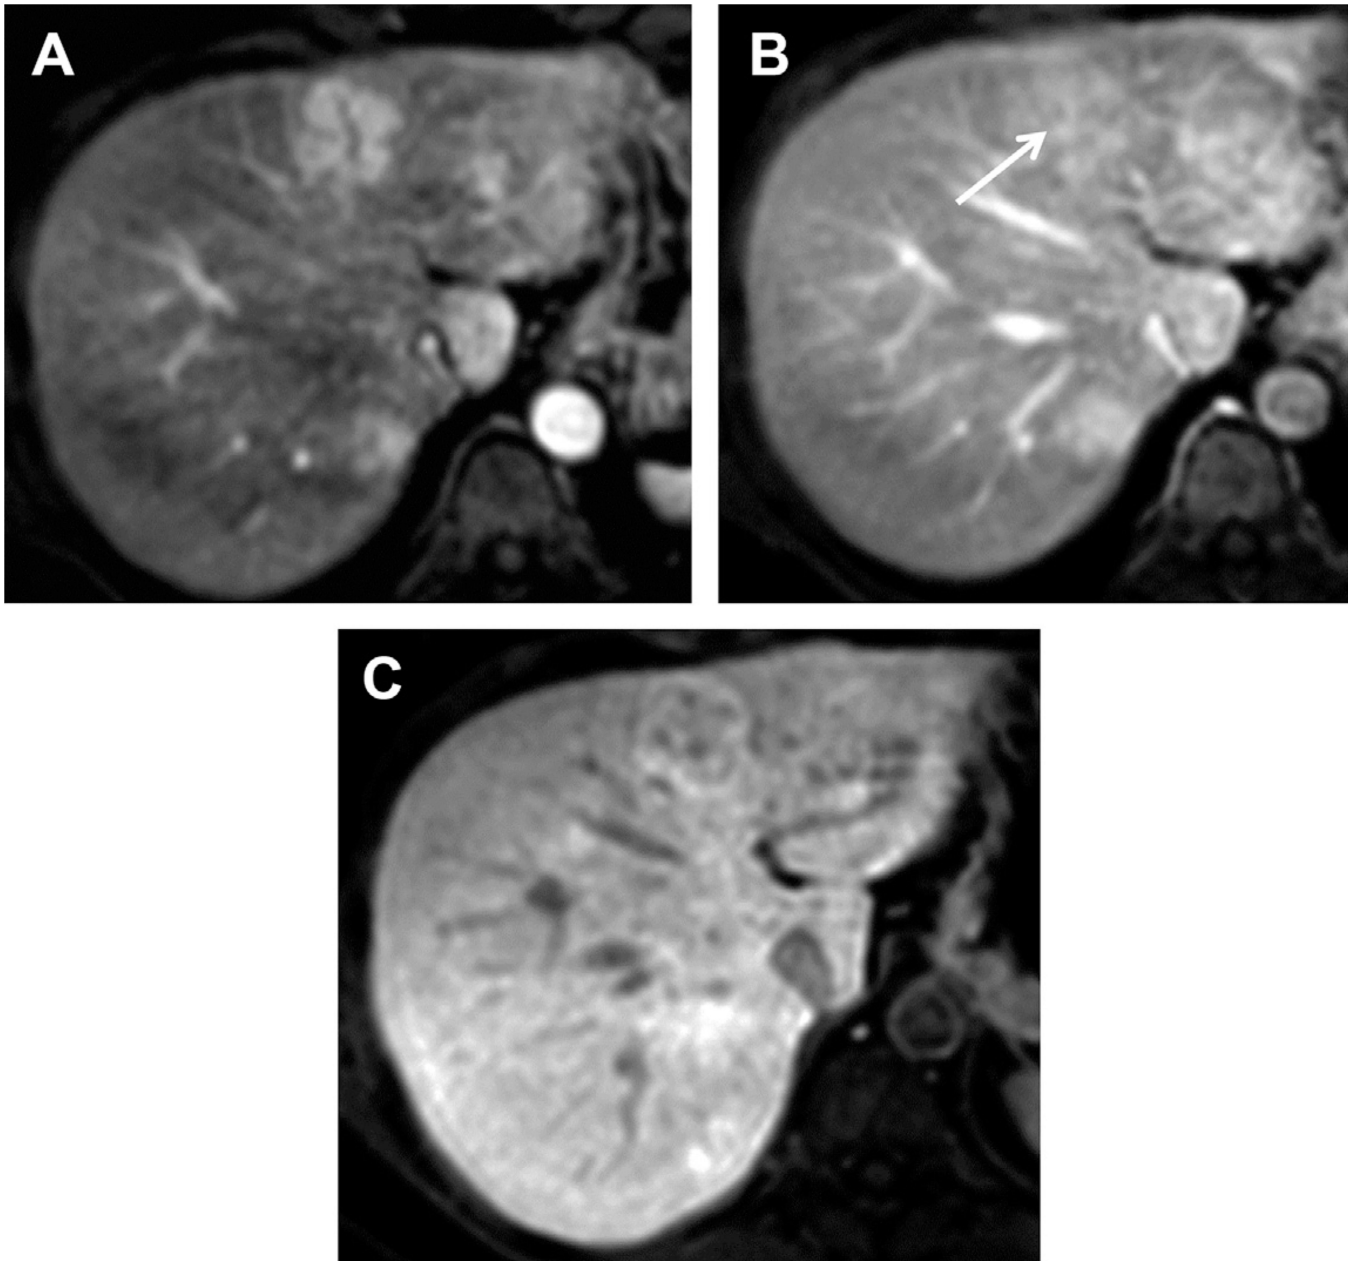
FNH with Gd-EOB-DTPA. (A, B) DCE-MR imaging during arterial and venous phases demonstrate a nodule with homogeneous enhancement on arterial phase, presenting a central hypovascular scar. The nodule becomes isointense to liver in the venous phase with enhancement of the scar (*arrow*). (C) Notice heterogeneous enhancement of the nodule during the HB phase.
